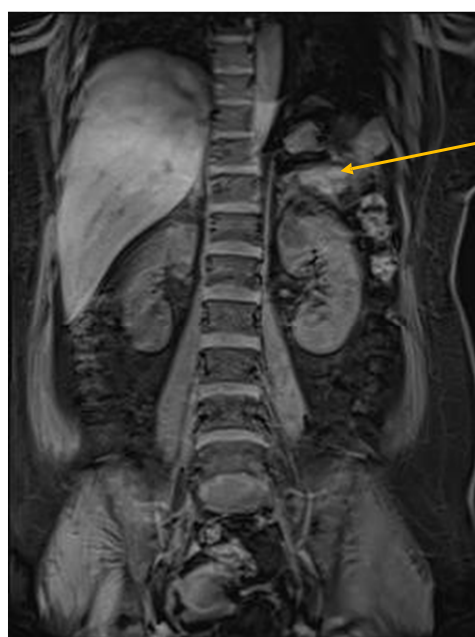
Contrast abdominal MRI
